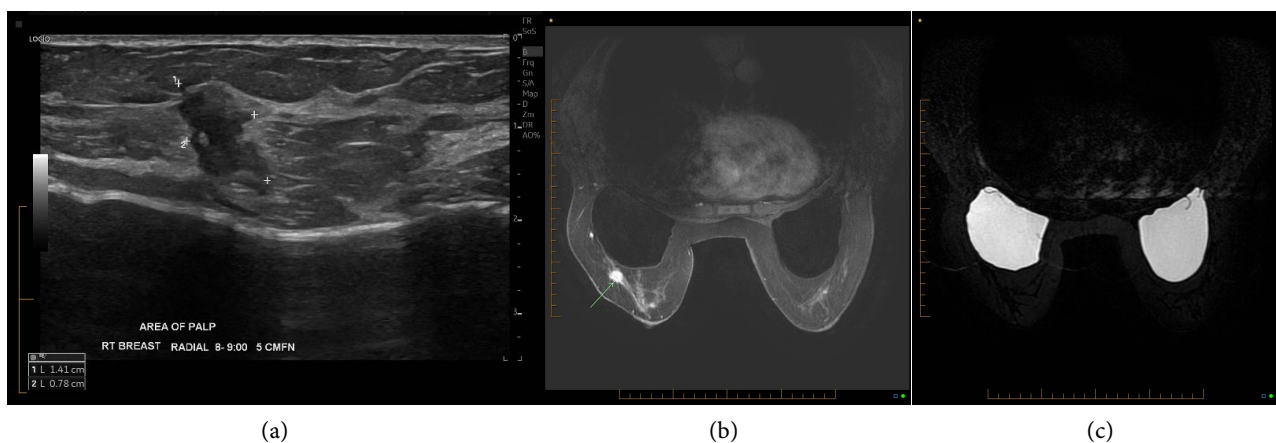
(a) Sonography of the right breast demonstrates a 1.4 cm angular lobulated solid mass at the 8:00 position, suspicious for carcinoma. The mass appears in close proximity to the underlying intact silicone implant, but no evidence of capsular invasion is seen. (b) Gadolinium-enhanced non-subtracted axial VIBRANT image shows a 1.4 cm avidly enhancing mass (arrow) in the 8:00 position representing a known carcinoma. Although the mass is located within 5 mm of the implant capsule, no capsular invasion is seen. (c) Axial silicone-sensitive (inversion recovery water saturated) sequences, performed pre-operatively for implant evaluation, confirm both prepectoral, single lumen implants to be intact. There are smooth contours, a symmetric shape, and normal radial folds. No intracapsular rupture or extracapsular free silicone is seen.
